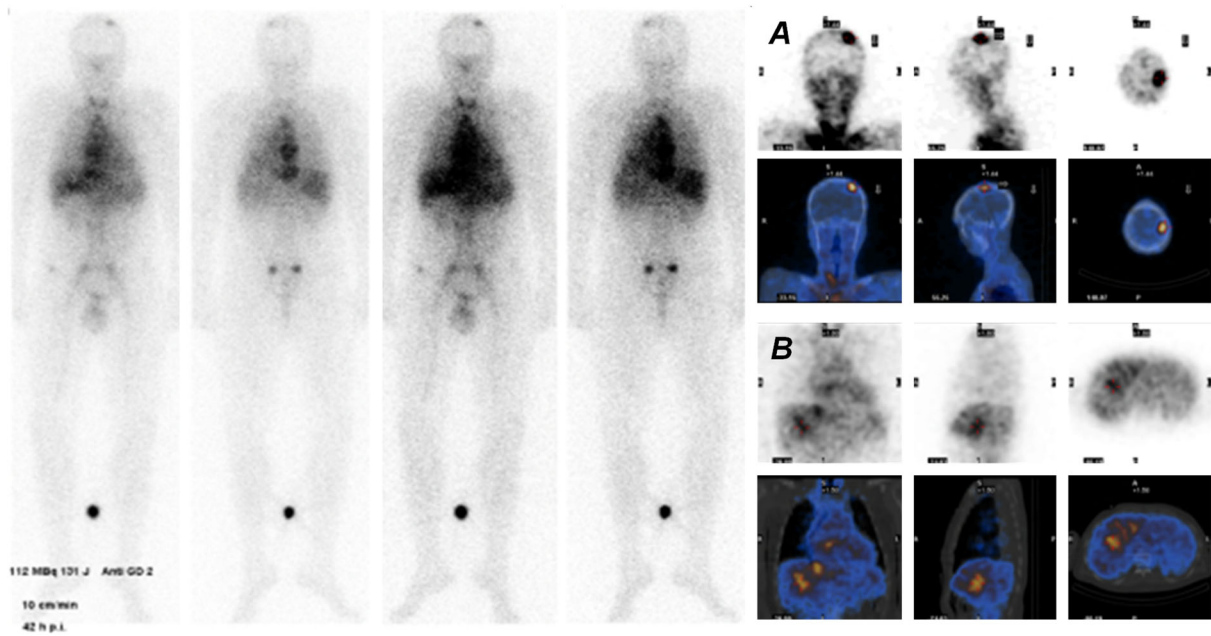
^{131}I - GD2-ch14.18 scan with additional SPECT/CT on day 2 from application demonstrates intense targeting of bone (A) and liver (B) tumor lesions in a patient with NB (patient No.1).
